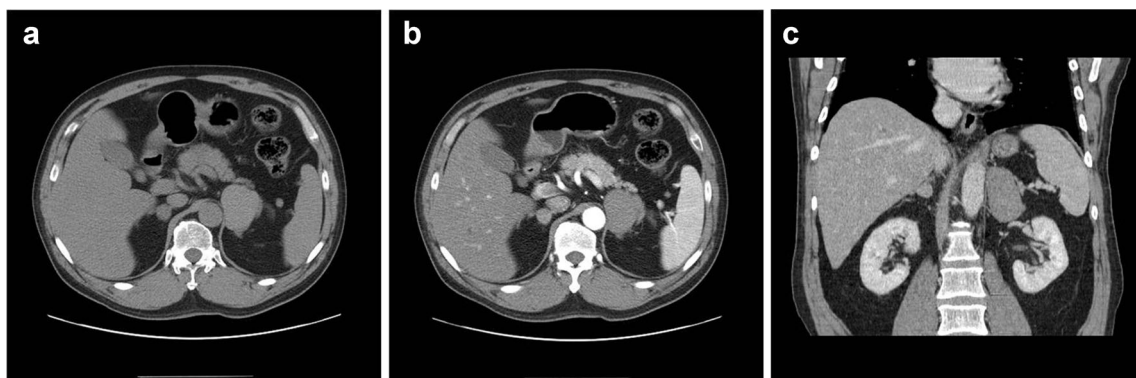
Axial precontrast (a), postcontrast (b), and coronal postcontrast (c) CT scan revealed a 5-cm, ovoid-shaped, well-defined, high-attenuation left paraadrenal mass without enhancement and 1-cm-sized enhancing nodule in the right adrenal gland
